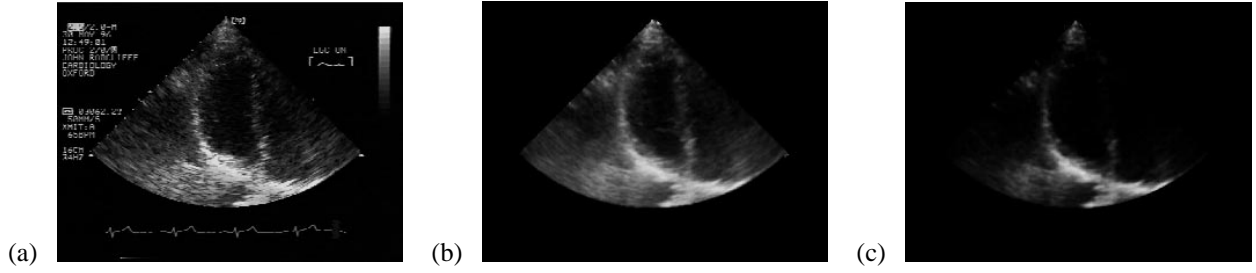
Noise reduction: (a) the original ultrasound image; (b) the image after the TDLMS filter is applied and (c) TDLMS filter followed by IBS filtering.
